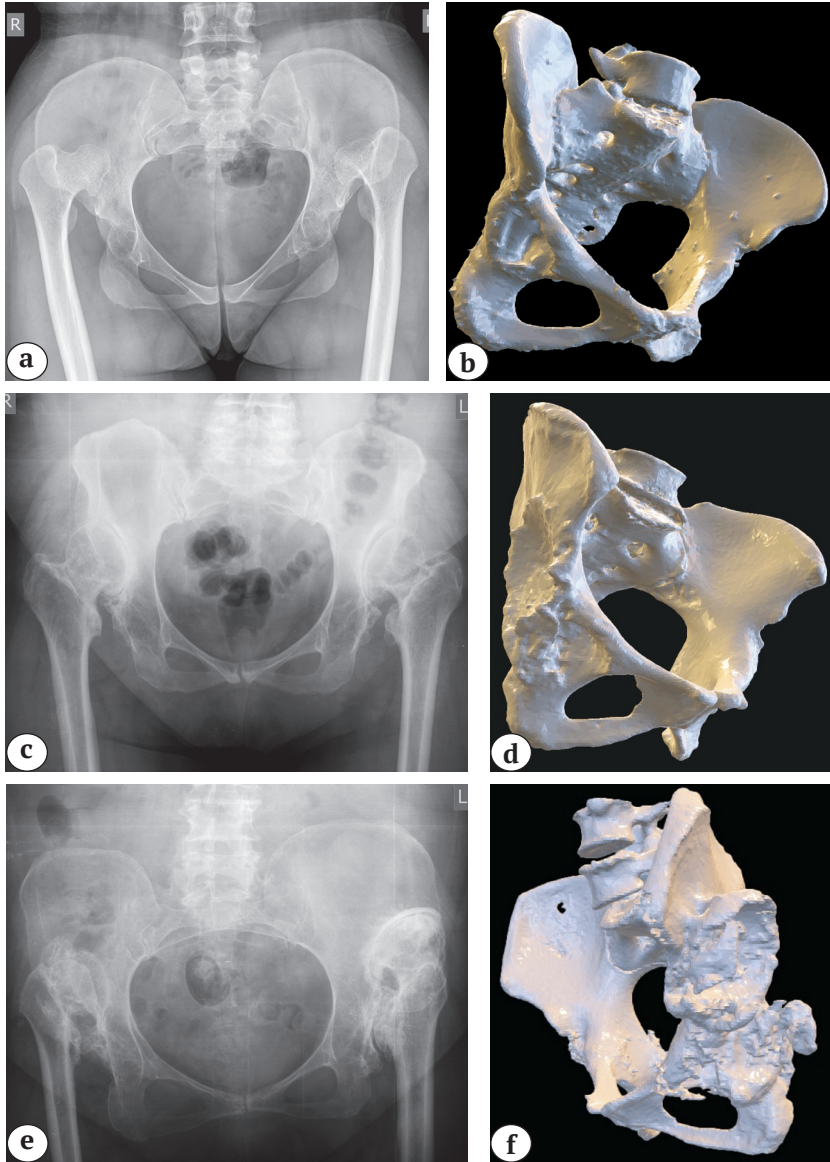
Pelvis X-rays and 3D visualization of the acetabulum in patients with different dislocation patterns:
